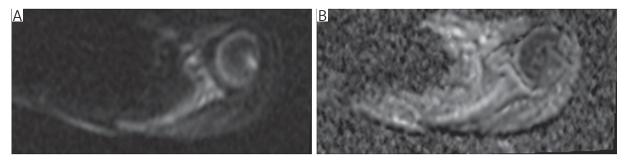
Left shoulder MRI, diffusion-weighted imaging (DWI), axial plane. High signal intensity of the scapula on DWI (A) without restricted diffusion on apparent diffusion coefficient (ADC) map (B)
